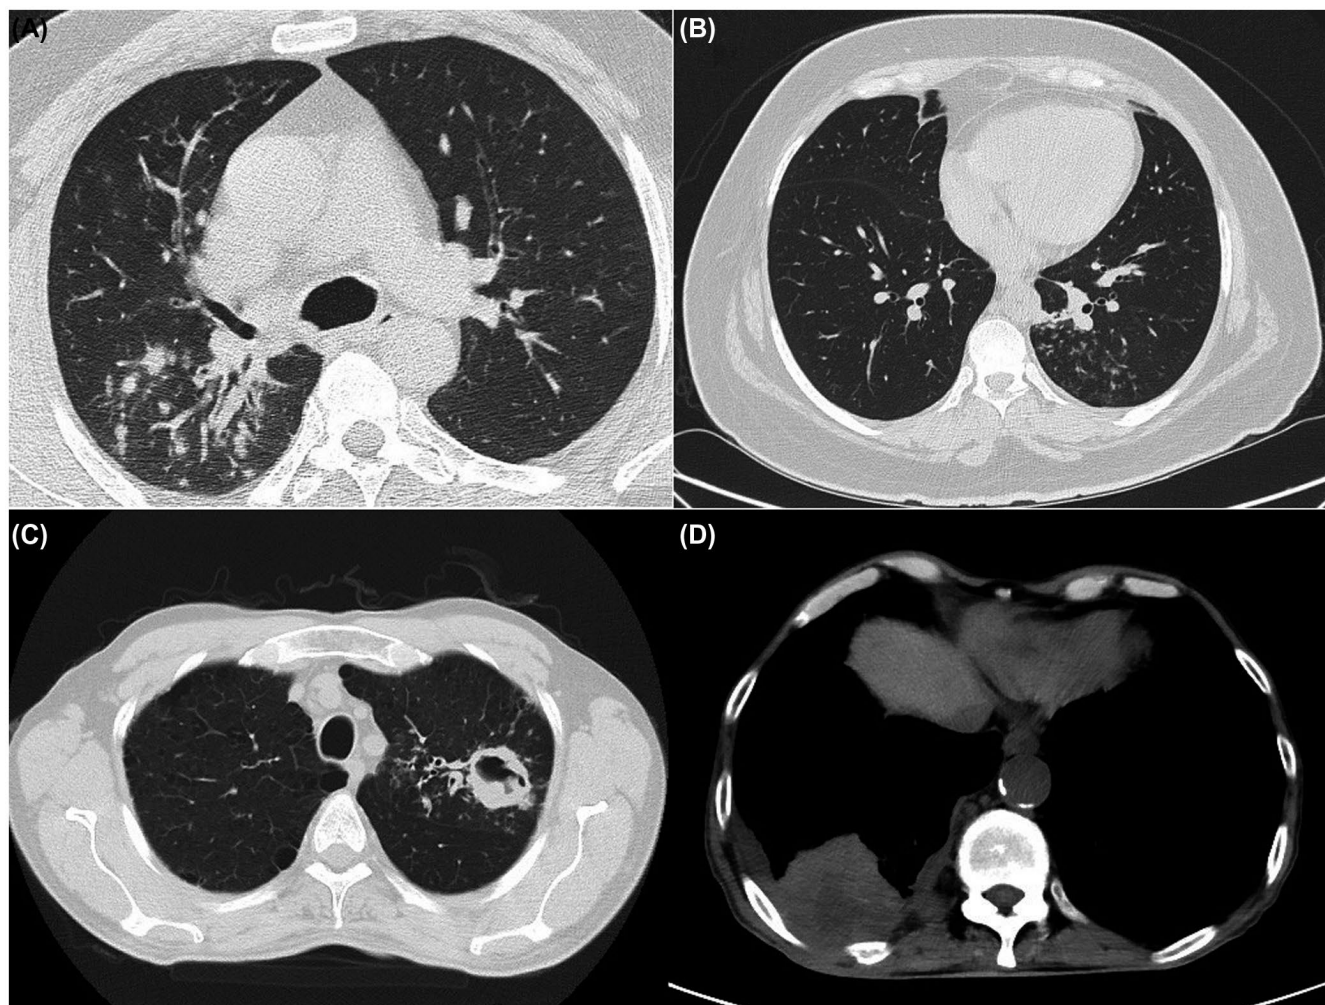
Of the RT-PCR-negative patients who underwent chest CT on suspicion of COVID-19 but whose findings were inconsistent with COVID-19. A, A 59-year-old male patient with centrilobular nodular infiltration in the superior segment of the right lung lower lobe. B, A 34-year-old female patient with a tree-in-bud sign in the posterior segment of the left lung lower lobe. C, A 48-year-old male patient with a thick-walled cavitary lesion with a peripheral tree-in-bud sign in the posterior segment of the left lung lower lobe, which is an indicative of tuberculosis or malignancy in the foreground. D, A 72-year-old male patient with a pleural-based mass lesion with a necrotic center posterior to the right lung lower lobe, accompanied by minimal pleural effusion
